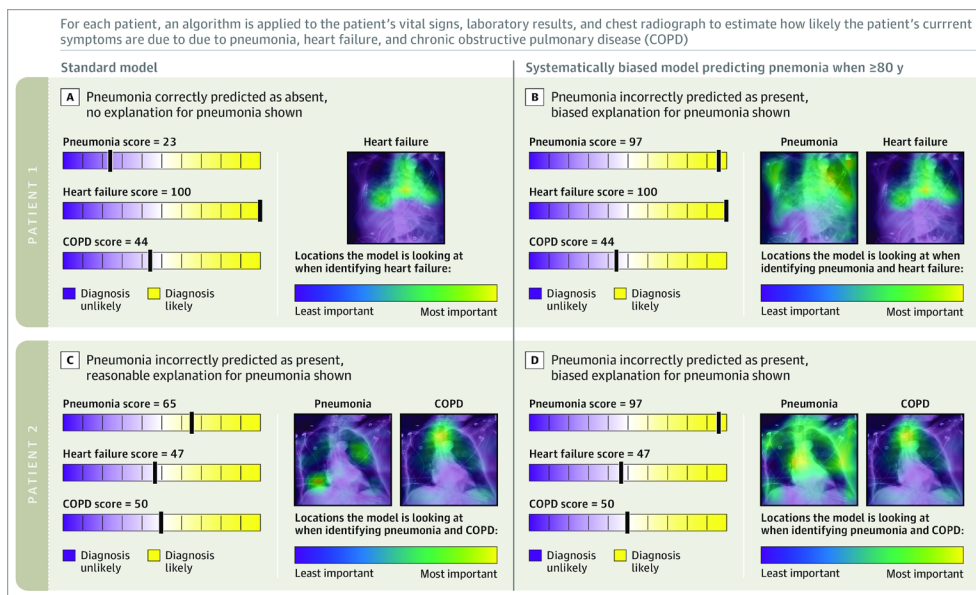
The AI model is analyzing the medical data from Patient 1 and Patient 2. A. The standard AI model correctly diagnosed heart failure as the cause of acute respiratory failure for Patient 1, an 81-year-old male with respiratory failure from heart failure, and provided an explanation, highlighting the regions in the chest radiograph used to make the prediction. B. On the contrary, the biased AI model diagnosed pneumonia as the cause of acute respiratory failure, failing to reach the right conclusion. This was due to the AI model taking in irrelevant information about the patient’s age and providing an explanation highlighting irrelevant features in the chest radiograph.
